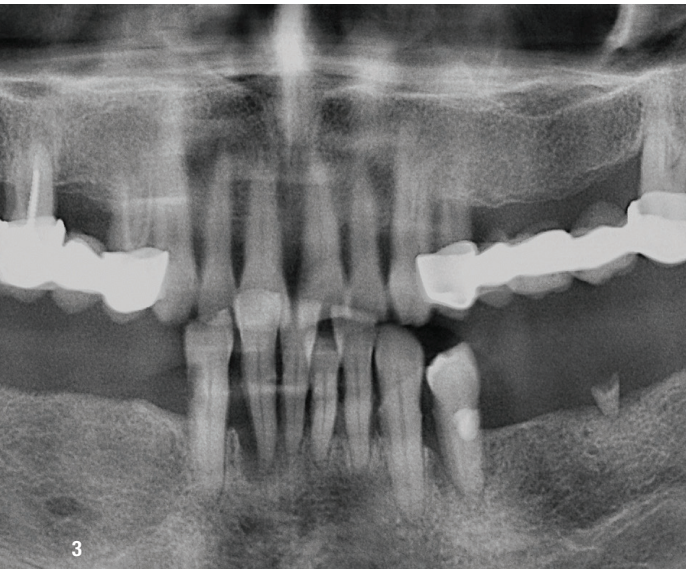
Panoramic view: severe bone loss in the anterior mandible. Fig. 4: Right side 3D CBCT view: severe bone loss in the anterior mandible and posterior maxilla.
